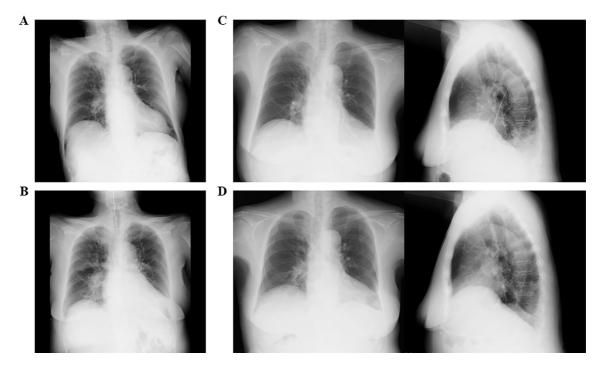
(A) Chest X-ray on admission. (B) Chest X-ray on development of nephrotic syndrome. (C) Chest X-ray on day 30 after admission at the time of dapaglifrozin initiation. (D) Chest X-ray on day 50 of admission.
